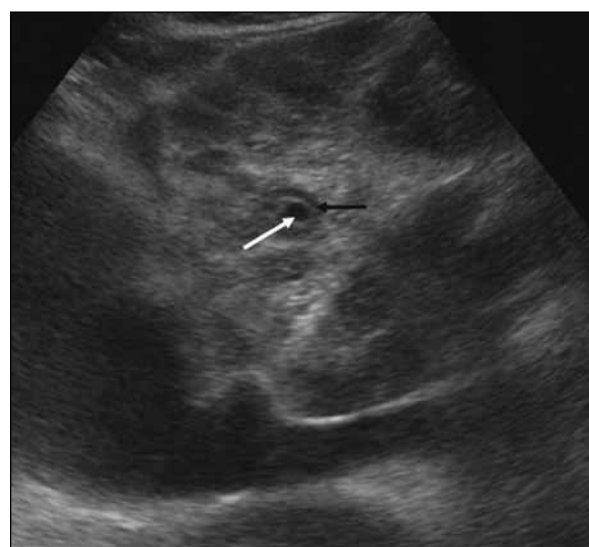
Grey-scale trasabdominal ultrasound (longitudinal scan) revealing 'clay-pipestem fibrosis'. Note the anechoic portal vein (white arrow) surrounded by an echogenic mantle of fibrous tissue (black arrow)
